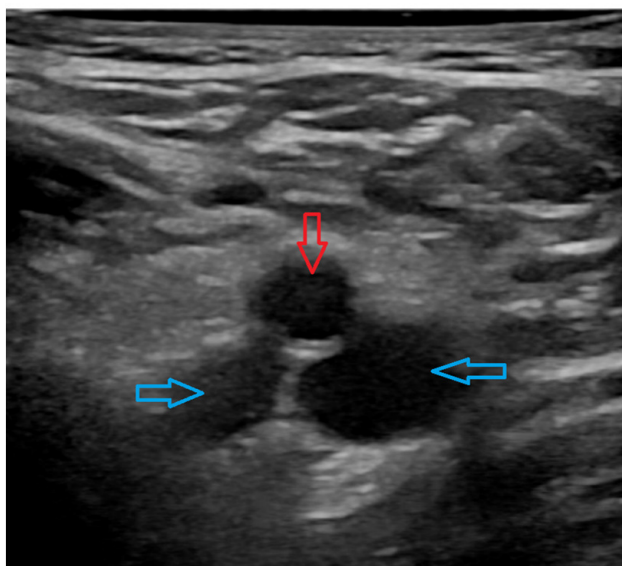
Ultrasound showing duplicated IVCs (blue arrows) and aorta (red arrow). The aorta has a more uniform, circular appearance, while IVCs have a more elliptical, collapsible appearance.
